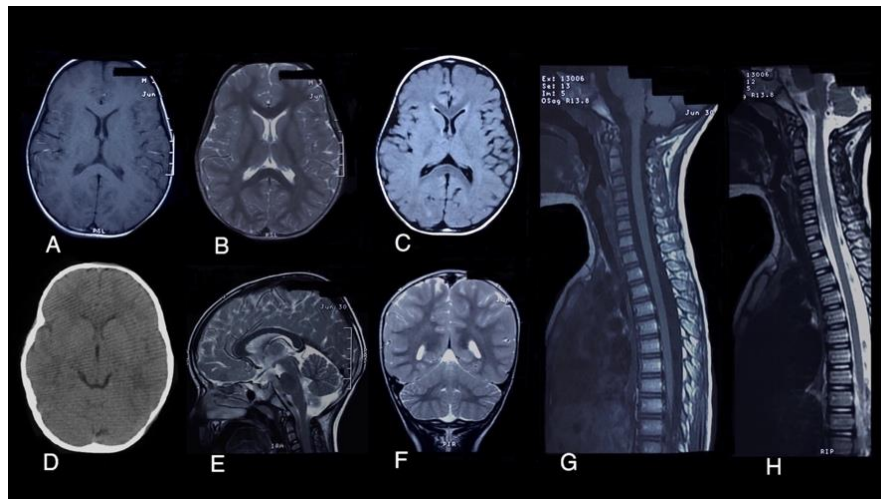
Neuroimaging in the patient showed normal findings. Brain Magnetic resonance imaging (MRI) images (A: Axial T1-Weighted image, B: Axial T2-Weighted image, C: Axial fluid-attenuated inversion recovery, E: Sagittal T2-Weighted image, F: Coronal T2-Weighted image), Brain computerized tomography (CT) scan (D: Axial view), Spine MRI (G, H: Comparison of sagittal T1 vs. T2- Weighted – Spine images)
